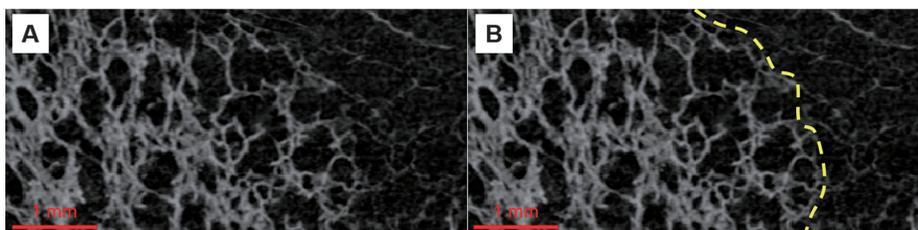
These Images were taken by micro-computed tomography
